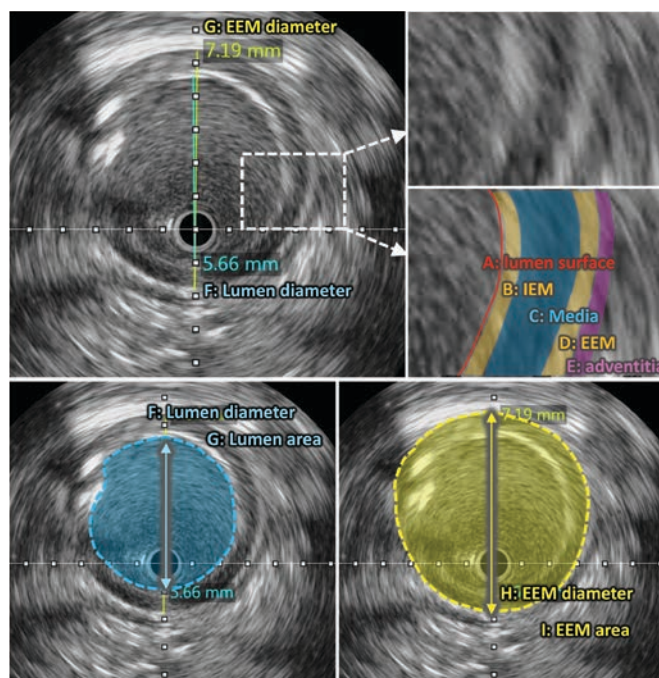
Definitions of intravascular ultrasound (IVUS) findings. IVUS provides real-time cross-sectional images of the vessel that cannot be visualized by angiography alone. By enabling detailed assessment of vessel diameter and plaque characteristics, IVUS complements angiographic findings and facilitates a more comprehensive understanding of the target lesion. IVUS allows visualization of the 3-layer structure of the arterial wall: intima, media, and adventitia (A–E). The media (C) is the most clearly identifiable layer and appears as a hypoechoic “black band”. Compared with coronary arteries, the medial layer of peripheral arteries is typically thicker. The internal elastic membrane (IEM, B) and external elastic membrane (EEM, D) are visualized as hyperechoic boundaries on the inner and outer margins of the media, respectively. The intima, including the luminal surface, is located internal to the IEM. Lumen diameter is measured as the distance from intima to intima (F). In quantitative vascular angiography, vessel diameter is commonly assessed based on the lumen diameter. Lumen area is measured by tracing the leading edge of the luminal surface (G), and the minimum lumen area is defined as the smallest cross-sectional area within the target lesion. The adventitia lies external to the EEM and appears as a hypoechoic region (E); however, it is often difficult to distinguish clearly from the surrounding tissue. Therefore, vessel diameter on IVUS is typically defined using the EEM diameter (H). Vessel area is measured by tracing the trailing edge of the EEM on a cross-sectional image and is referred to as the EEM area (I).
